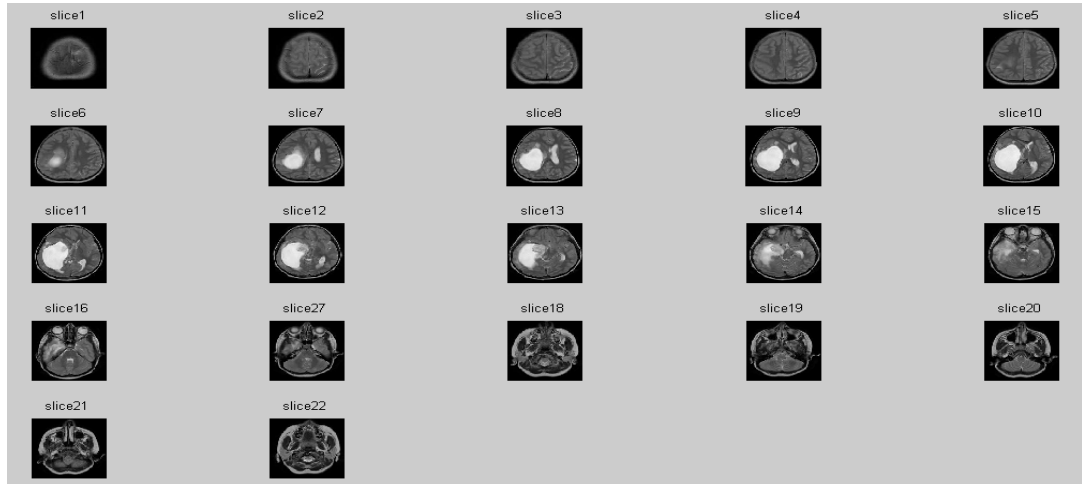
Set of Brain Slices obtained by MRI Scan
